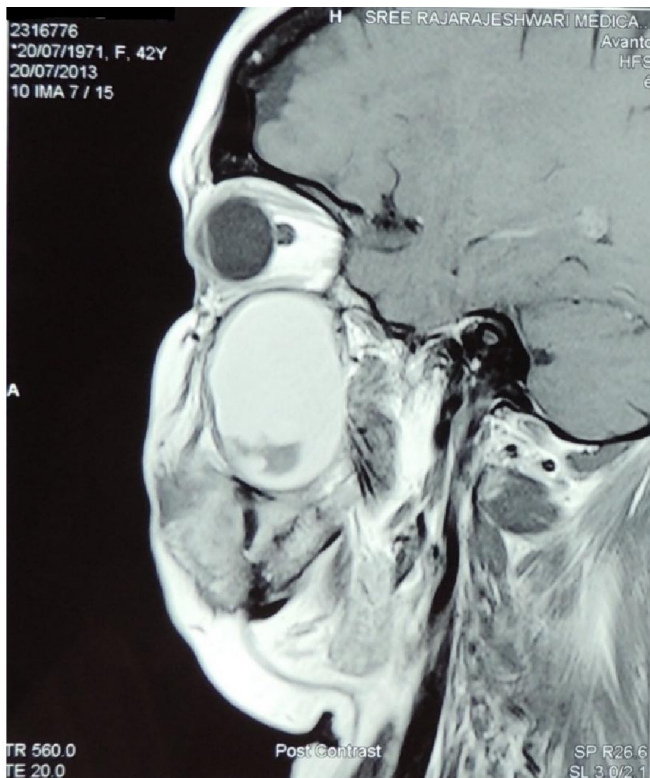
Post-contrast T1 weighted (MRI) sagittal section revealing a non-enhancing hyperintense collection involving right maxillary sinus
